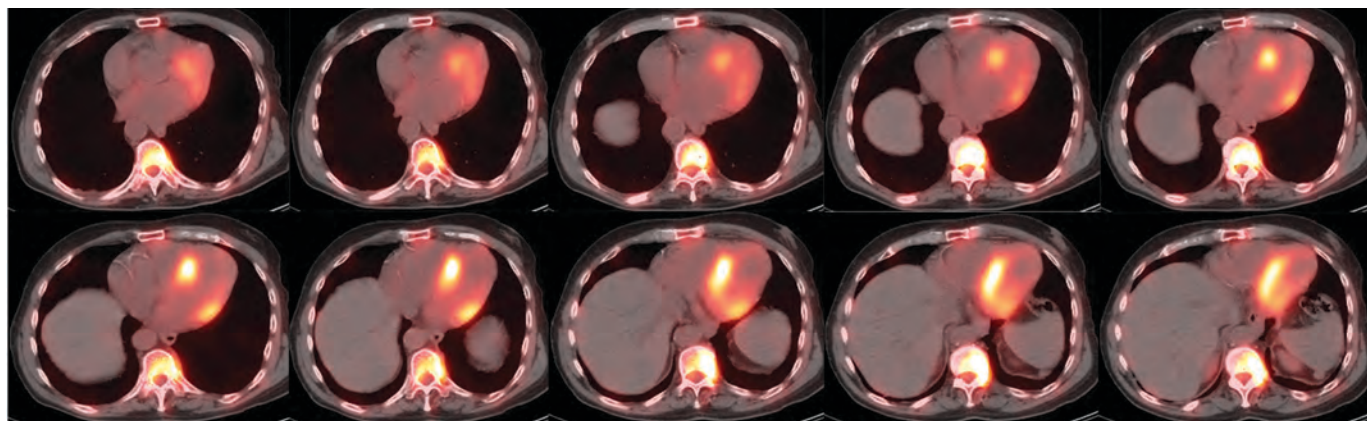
ATTR amyloidosis NM imaging. SPECT/CT Tc-99m PYP scan demonstrating Grade 3 uptake (greater than rib uptake with mild/absent rib uptake). H/CL = 2.62. There is no significant blood pool present.
